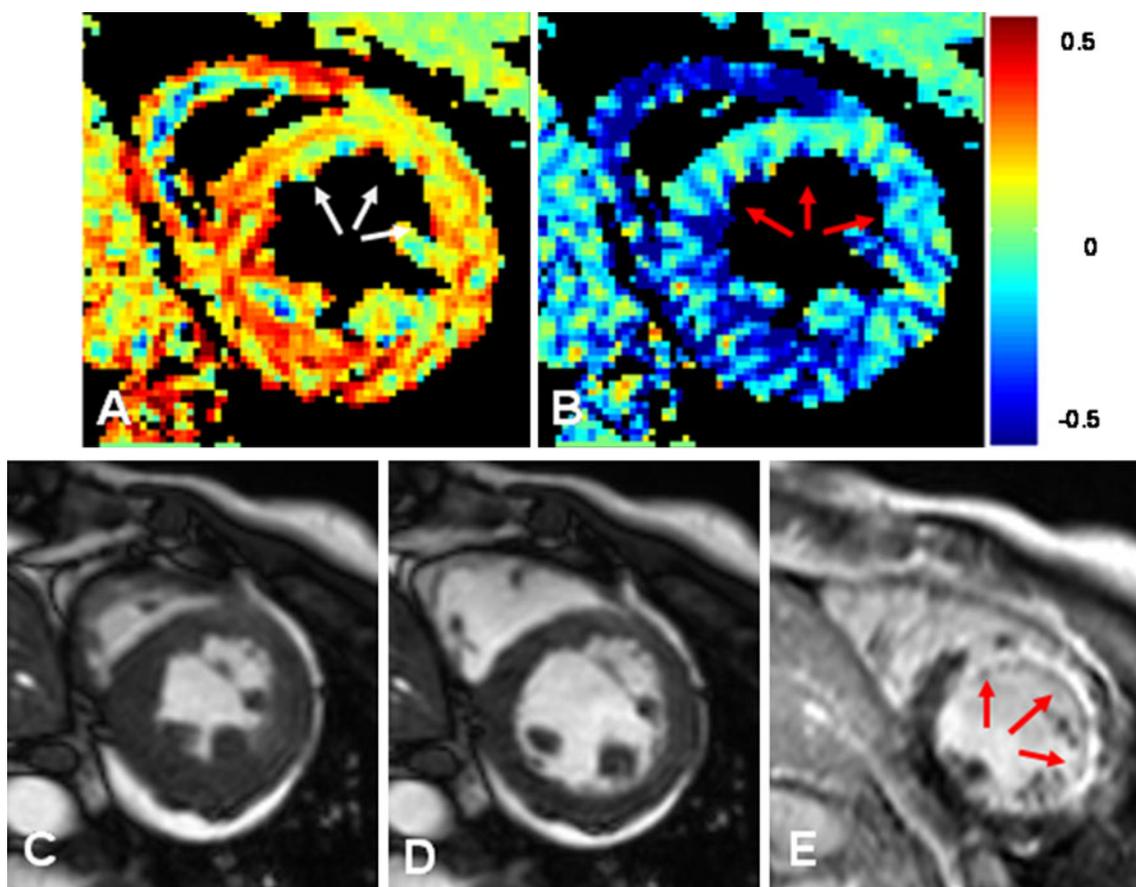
43-year-old man with anteroseptal old MI. e1 strain map (a), e2 strain map (b) obtained by DENSE MRI, cine MR images during systole (c) and diastole (d), and LGE MRI (e). Impaired myocardial strain was clearly observed in anteroseptal wall on strain maps
